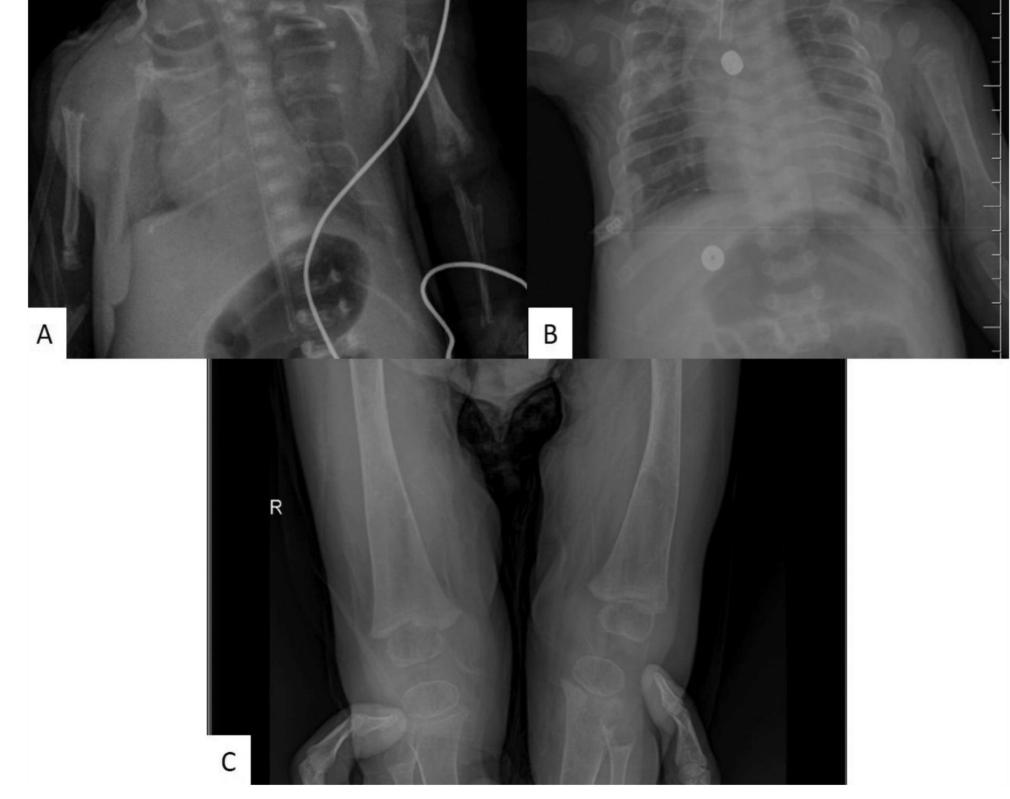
X-ray of the patient; (A) before treatment, (B and C) at 12 months of treatment. Note the general improvement of mineralization and of rachitic changes with asfotase alfa enzyme replacement therapy
